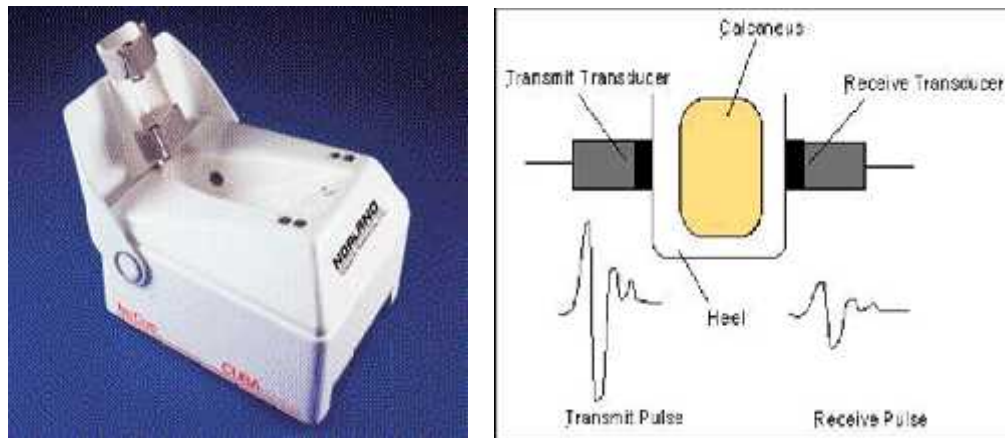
Calcaneal ultrasound
